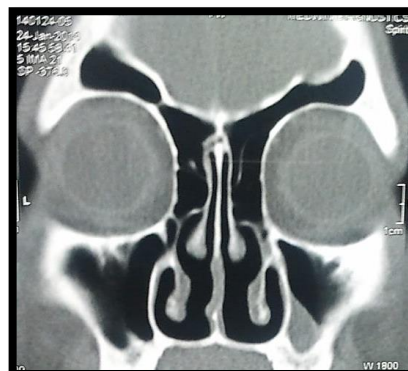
CT scan showing enlarged ethmoid bulla with mild mucosal thickening in ethmoid infundibulum.
